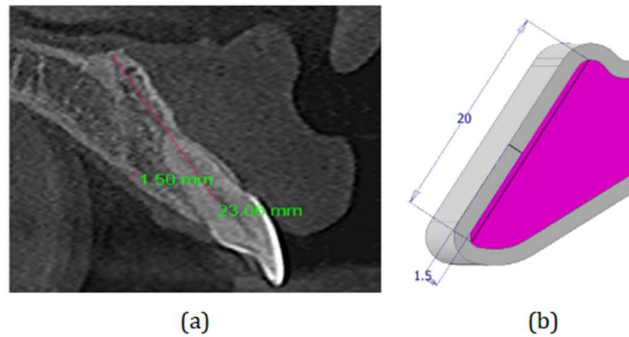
(a) CBCT anterior maxilla (b) 3D Inventor tulang anterior maxilla
